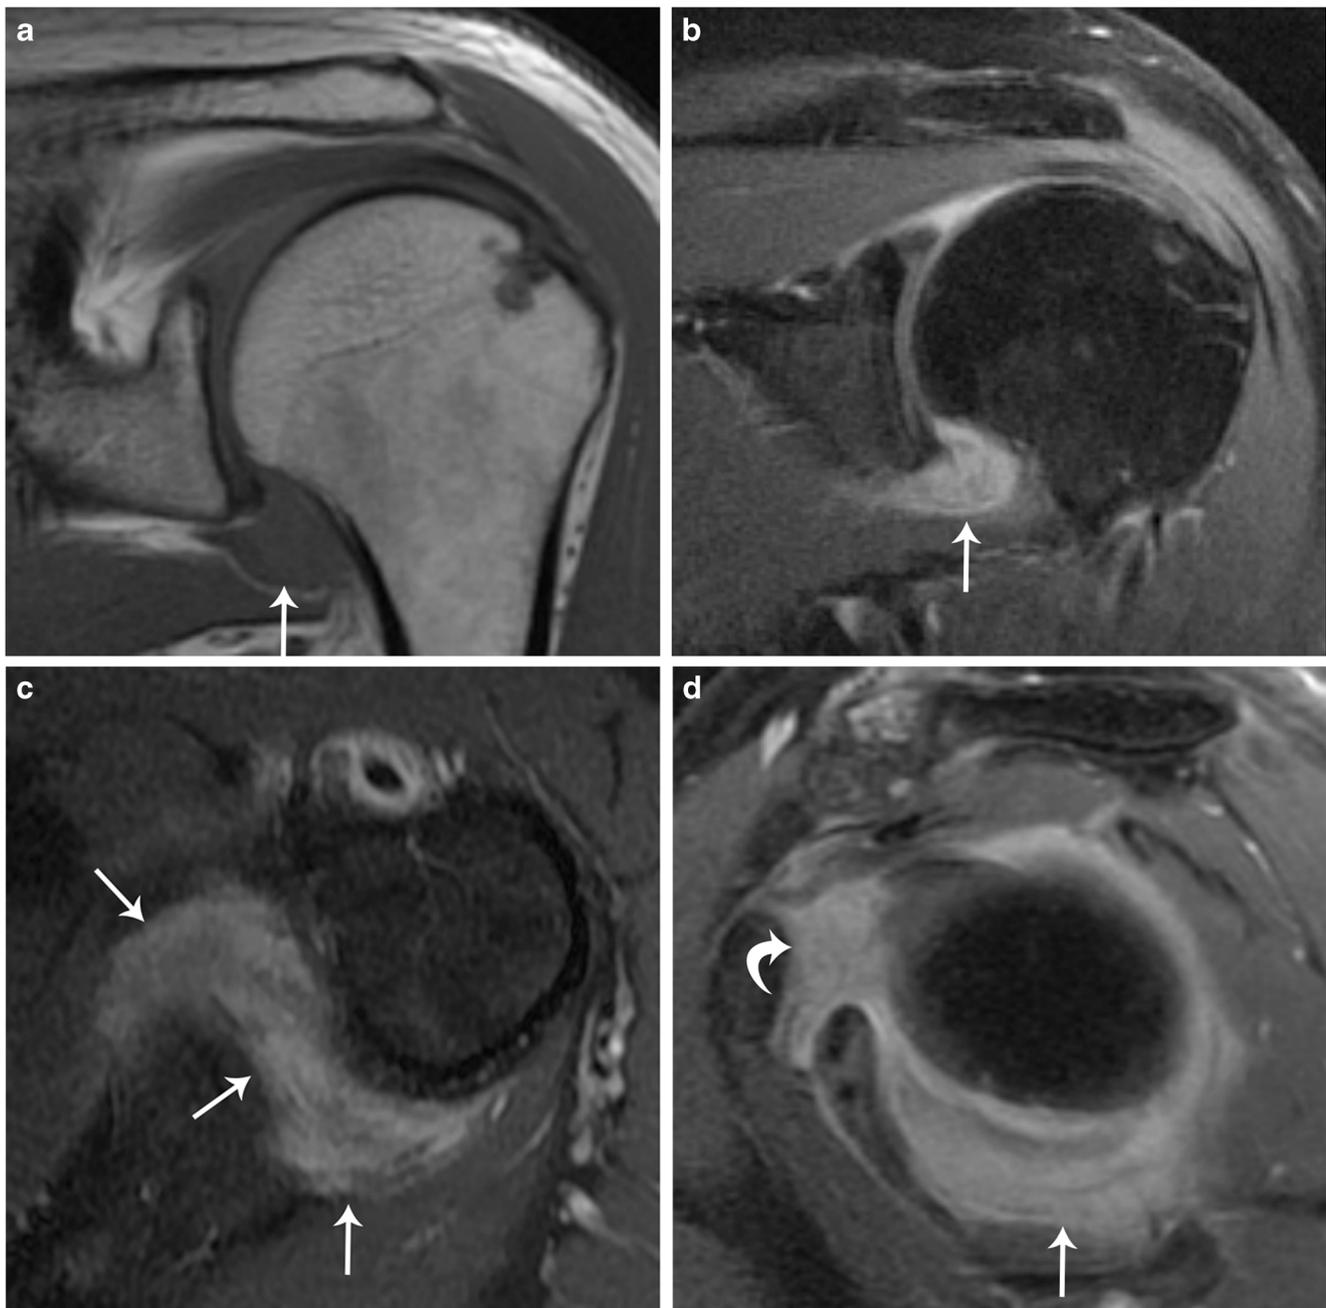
A 61-year-old man with left shoulder pain and a limited range of motion. a Coronal oblique T1 pre-contrast and b coronal oblique, c axial, and d sagittal oblique T1 FS post-contrast MR images show severe
